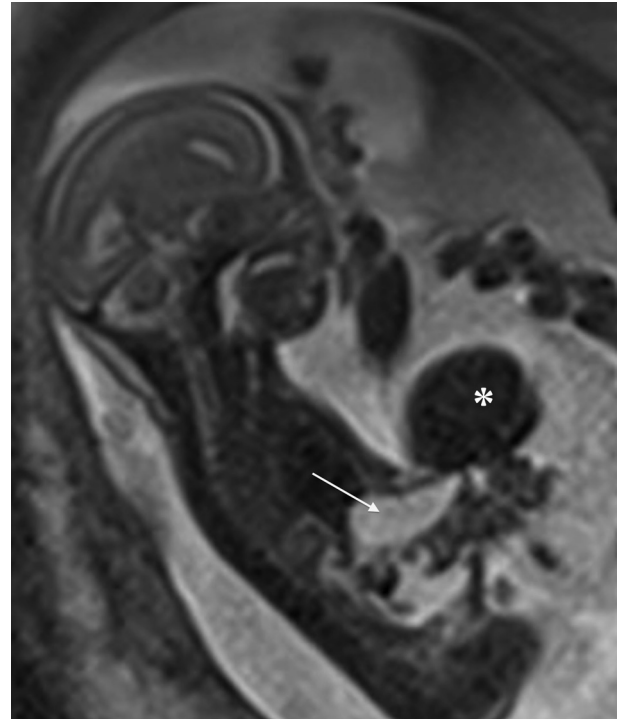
Exomphalus, 20 weeks' gestation. T2-weighted image, sagittal section. All the liver *, most of the stomach (arrow) and some of the bowel are outside the fetal abdomen.
